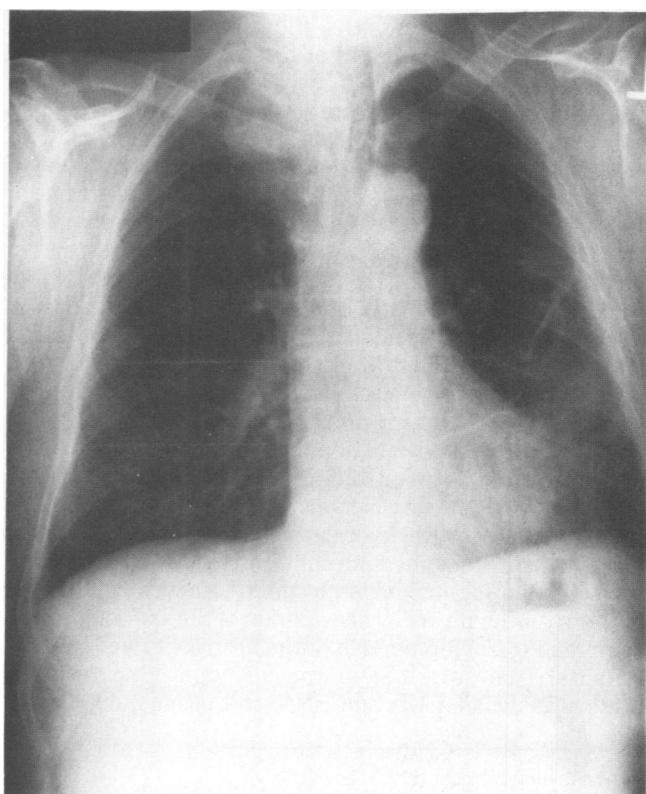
A posteroanterior radiograph of the chest shows a right apical-superior mediastinal mass and tracheal deviation to the left.
